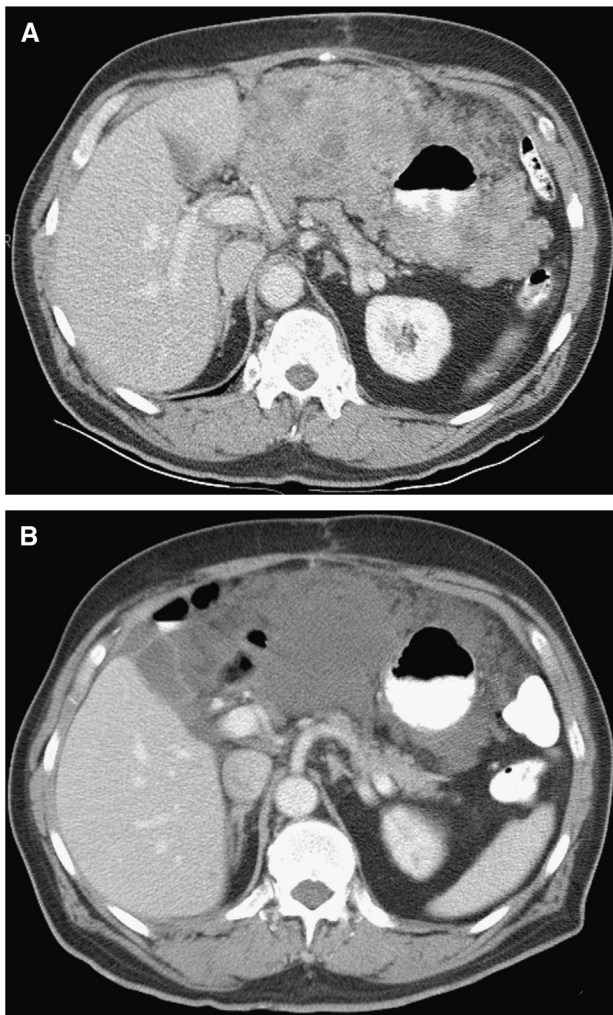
Typical appearance of gastrointestinal stromal tumor (GIST) in a 70-year-old man with an unresectable GIST of the stomach. (A) A pretreatment CT image showed a very large hyperdense mass completely surrounding the stomach. Endoscopic biopsy was negative for malignancy. (B) The mass became hypodense and homogenous on CT obtained 8 weeks after imatinib treatment. Courtesy of Haesun Choi, MD, The University of Texas M. D. Anderson Cancer Center.
